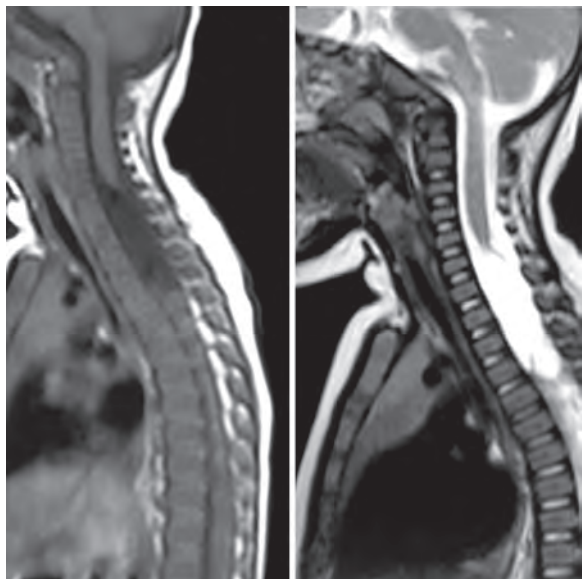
Spinal arachnoid cyst in the thoracic region (Sagittal MR images)
